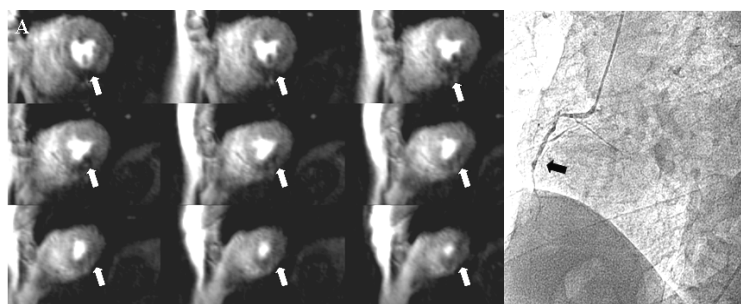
Patient example with nine out of sixteen consecutive slices of 3D CMR stress perfusion images; basal (top left) to apical (bottom right). (A) Inferior hypoperfusion from apical to basal slices (white arrow). (B) Invasive X-ray angiography confirming an occluded right coronary artery (black arrow).
